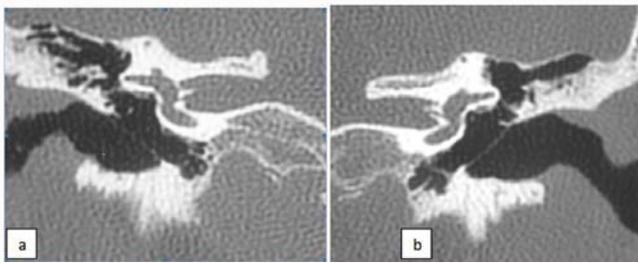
CT scan of the right (a) and left (b) temporal bones, coronal section: bilateral agenesis of the stapes and vestibular window.
